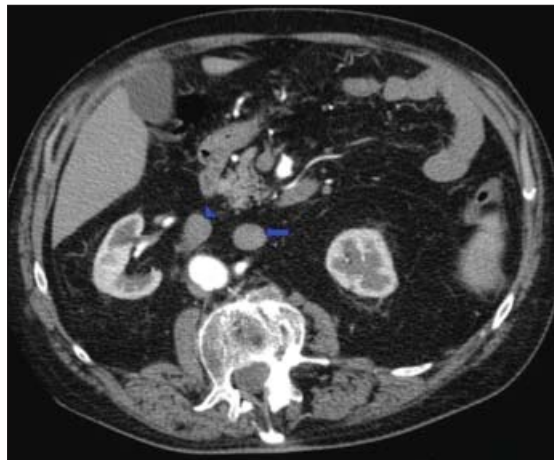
Axial abdominal angio-CT scan shows the abdominal aorta surrounded by the right inferior vena cava (arrowhead) and a similar left formation (arrow), suggesting an abnormality of vena cava development.
